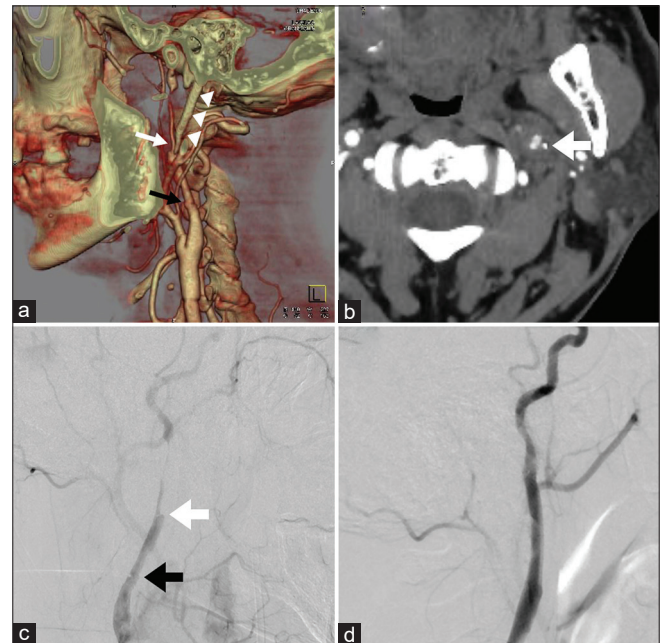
(a) The post-operative segment of the carotid artery was patent without stenosis on computed tomography angiography, while severe stenosis of the left internal carotid artery (ICA) (white arrow) was observed 2.5 cm distal to the endpoint of carotid endarterectomy (CEA) (black arrow), which suggested distal carotid artery dissection (CAD). The tip of styloid process (arrow heads) located at the beginning of the stenosis. (b) On axial image, the tip of the elongated styloid process (arrow) was adjacent to the ICA. (c) Carotid artery angiography also showed severe stenosis (white arrow) beginning 2.5 cm distal to the endpoint of CEA (black arrow) and confirmed distal CAD, which extended about 3 cm additionally distally. (d) Anterograde blood flow was restored after the two stent placements.
